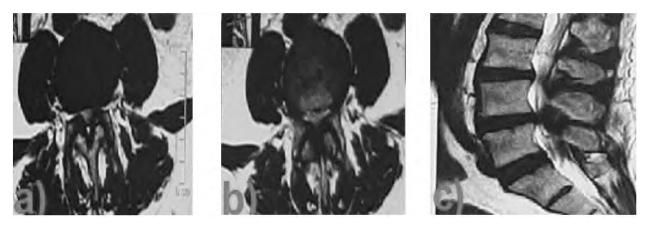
Showing pre-operative MRI axial (A&B), sagittal (C) with sever stenosis with hyper trophied facet.
